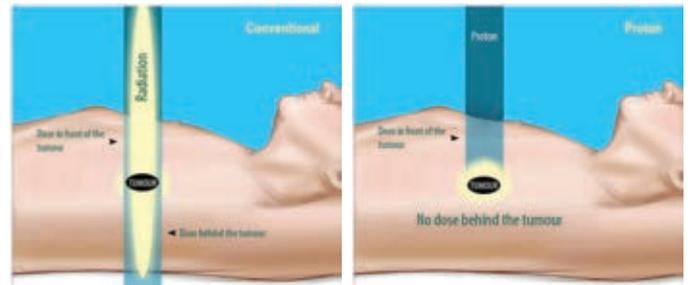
Comparison of radiation dosage paths between PBT and conventional X-ray radiotherapy (source: <http://www.proton-cancer-treatment.com/for-patients/advantages-of-proton-therapy/>).
